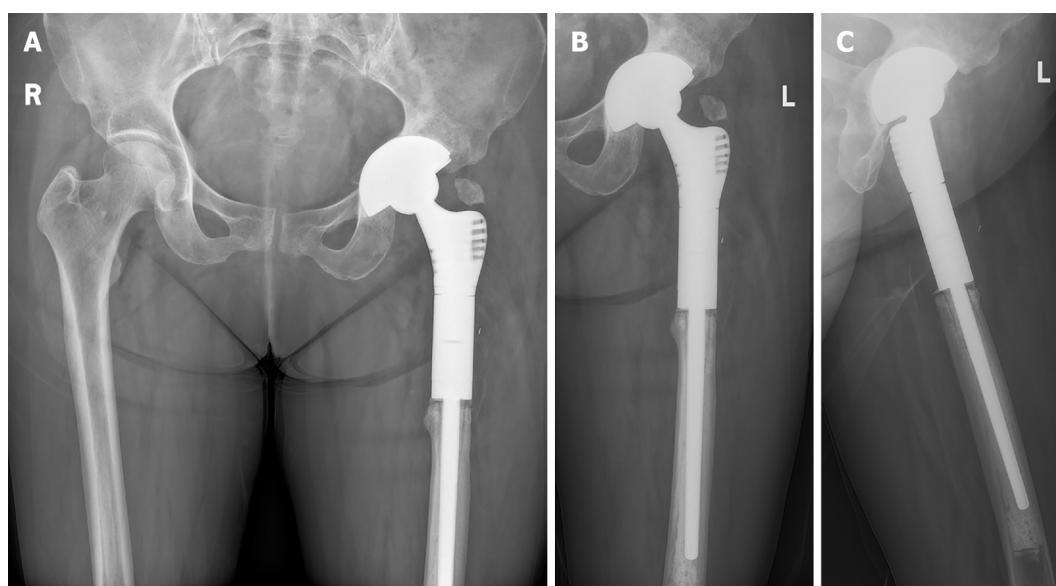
Radiographs of the pelvis taken 20 mo after the second-stage surgery. A: Pelvic plane; B: Anteroposterior plane; C: Lateral plane.
